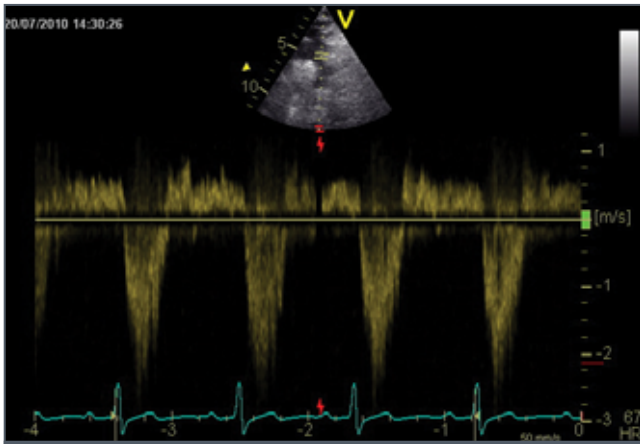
PW Doppler in the aortic arch on a suprasternal long axis view via transthoracic echocardiography.
